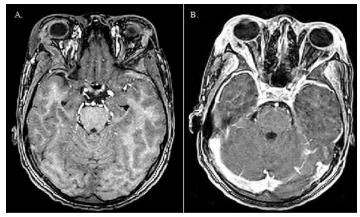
MRI of orbits and facial bones, T1 vibe axial images pre-(A.) and post-contrast (B.). Periorbital stranding (R>L) with extension into bilateral extraconal spaces and apparent lateral rectus involvement.
